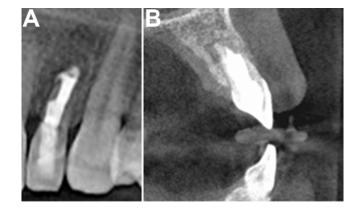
(A) Post-op CBCT (coronal section). (B) Post-op CBCT (sagittal section). CBCT, cone beam CT; Post-op, postoperative.
